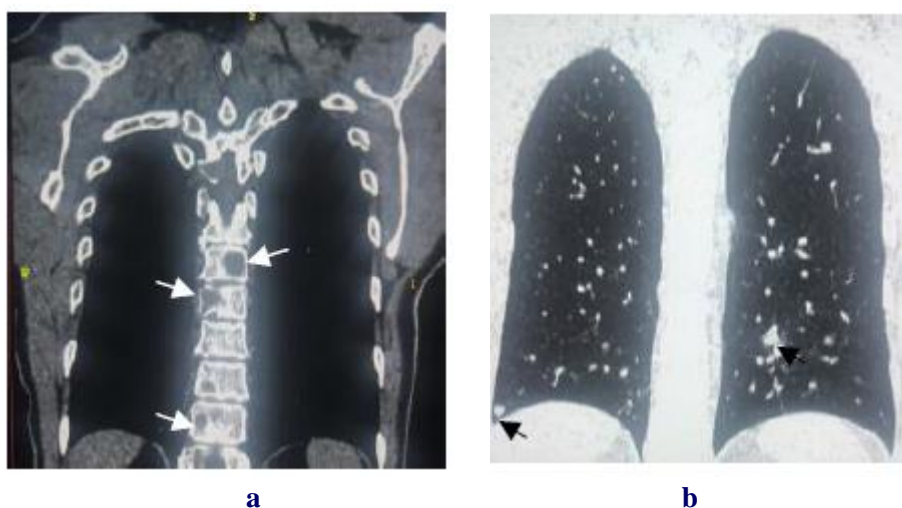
a) Computed tomography of the thorax with window for bone in which lithic lesions are observed in multiple vertebral bodies of the thoracic spine. White arrows. b). Computed tomography of the thorax with a window for the lung in which bilateral pulmonary nodules are observed, of dispersed distribution and in variable size. Black arrows.
